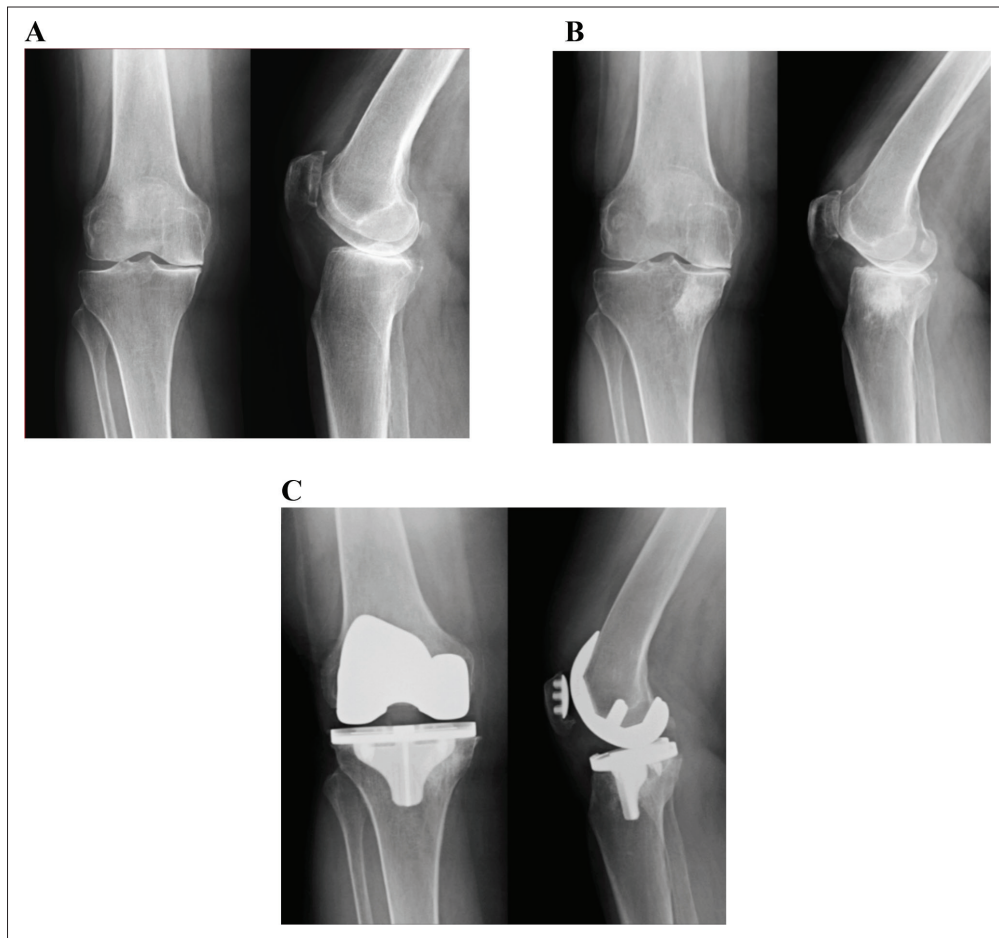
Osteoarthritis in a patient initially treated with subchondroplasty, followed by total knee arthroplasty without complication. (A) Preoperative radiographs of a patient with osteoarthritis prior to subchondroplasty. (B) Postoperative radiographs of the same patient following subchondroplasty. (C) Postoperative radiographs one year postoperative total knee arthroplasty following failed subchondroplasty.
